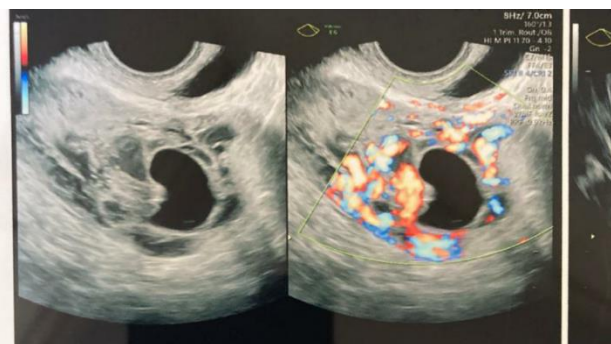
Doppler showing ring of fire sign.
